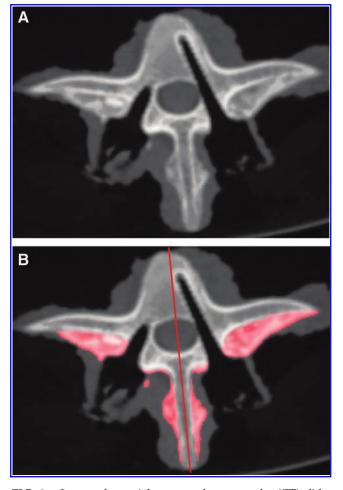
Image of an axial computed tomography (CT) slide. (A) Blurred image on which newly formed bone is visible against the transverse processes and spinous process. The anatomic border of the vertebra can be clearly distinguished from the new bone. Note the position of the removed pedicle screws. (B) Semi-automatic selection of the newly formed bone (pink). Red line divides vertebrae into a left and right side. By selecting the newly formed bone on all axial slices, the volume of newly formed bone of each spinal segment was calculated. Color images available online at www.liebertpub.com/tec
